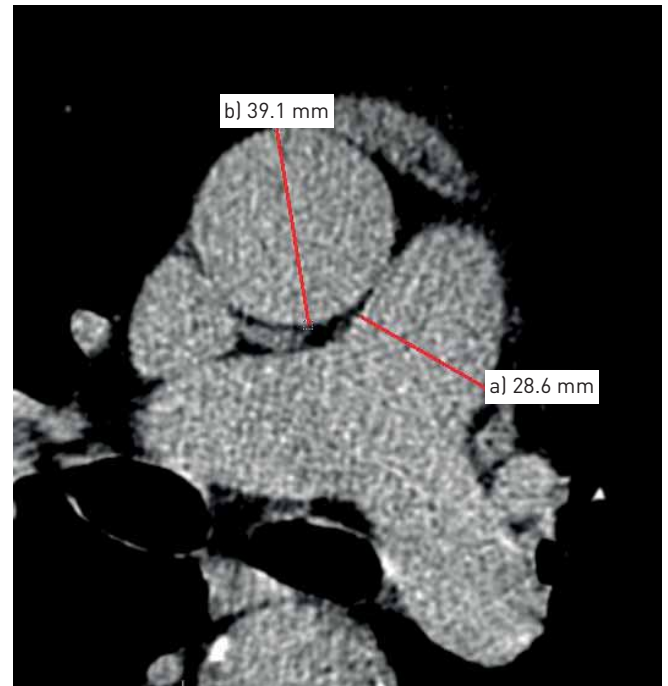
Example measurement of the diameter of a) the pulmonary artery (28.6 mm) and b) the ascending aorta (39.1 mm) at the level of bifurcation of the pulmonary artery on the same slice of a noncontrast computed tomography examination.
